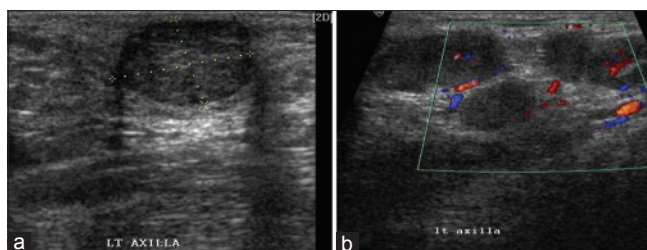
Breast USG in a 40 years female shows an enlarged intramammary hypoechoic lymph node in left axillary tail region with loss of fatty hilum (Fig.8a). Another patient with left axillary lymphadenopathy shows multiple enlarged hypoechoic lymph nodes on USG with increased vascularity on color Doppler (Fig. 8b)
